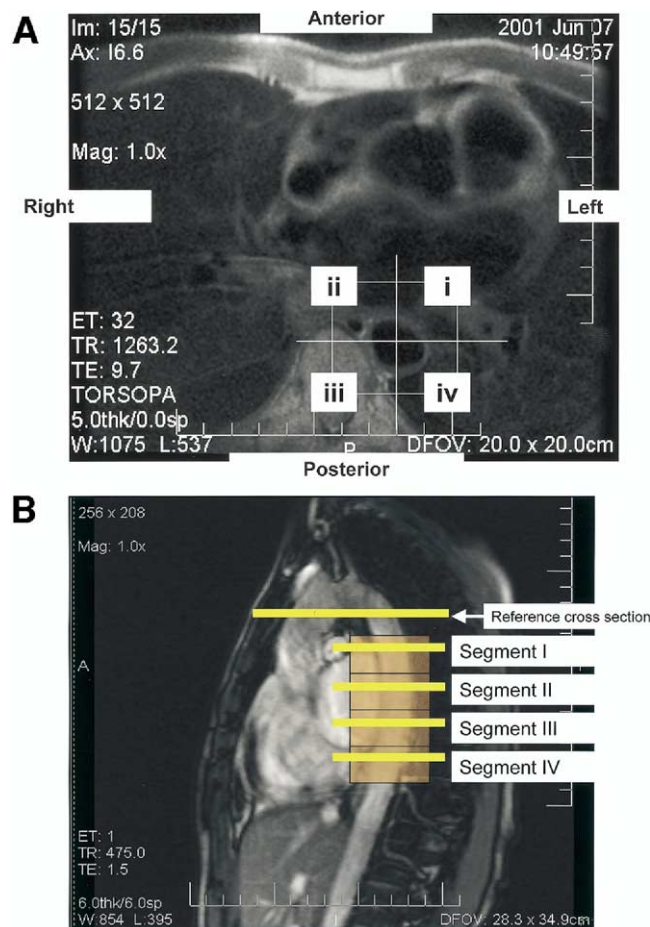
(A) Location of the predefined quadrants i, ii, iii, and iv relative to the right, left, anterior, and posterior side of the patient. (B) Axial distribution of the four predefined segments (orange), each 2 cm in length, summarizing the wall thickness data beginning 1 cm from the reference cross section, located at the exit of the aortic arch. Segment I is located 1 to 3 cm from reference cross section; segment II is located 3 to 5 cm from reference cross section; segment III is located 5 to 7 cm from reference cross section; and segment IV is located 7 to 9 cm from reference cross section. The location of phase-contrast velocity measurements, in yellow, is positioned in the center of the defined segments. Magnetic resonance imaging slice thickness for the velocity and wall velocity measurements was 5 mm.
